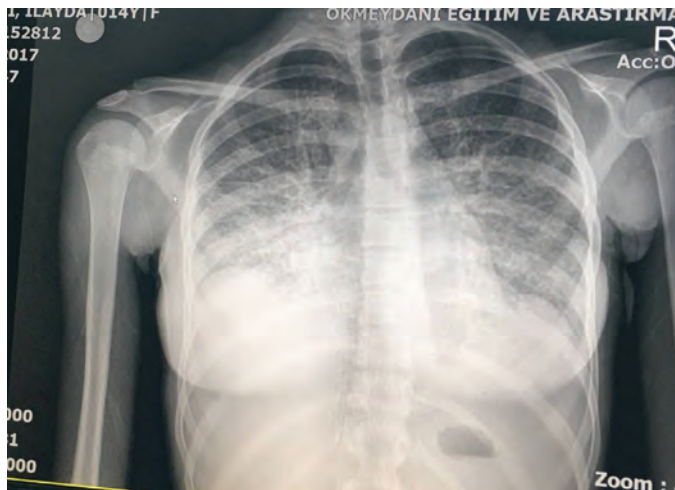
Patient's chest X-Ray
